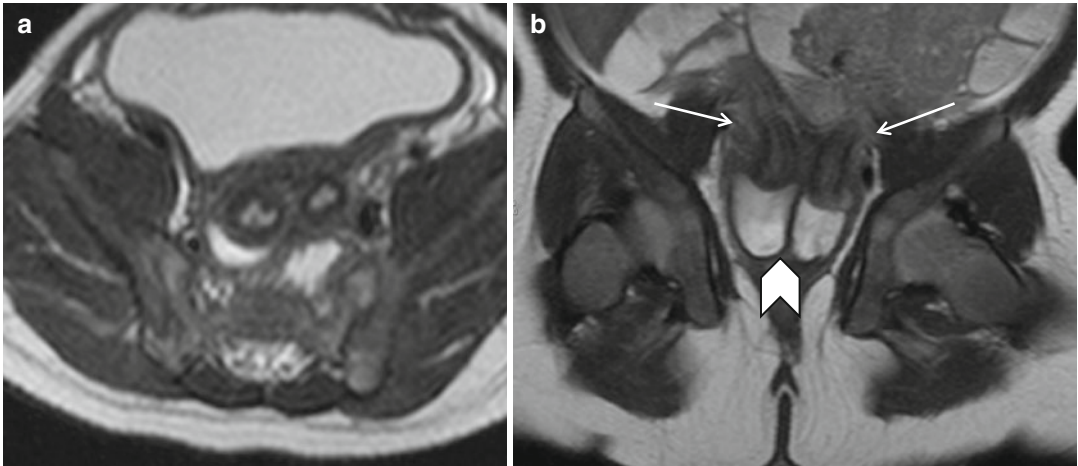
Didelphys uterus (III). Fast spin-echo T2-weighted images on sagittal (TR/TE 4530/90) (a) and coronal plane (TR/TE 3310/93) (b) show two separate
